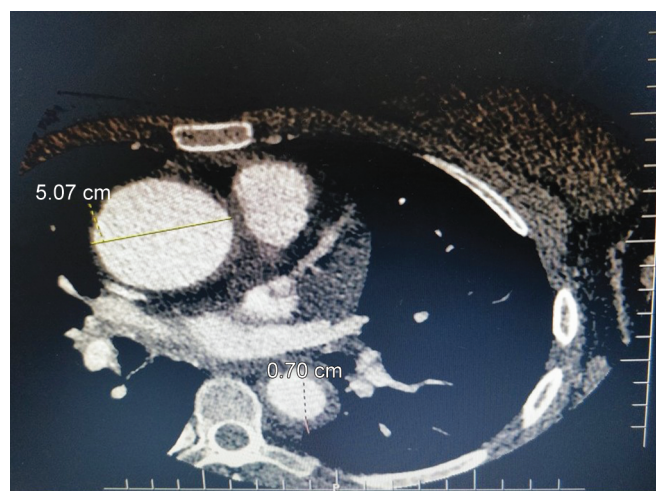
A CTA showing diffuse circumferential thickening of aortic wall and aneurysm of ascending aorta
